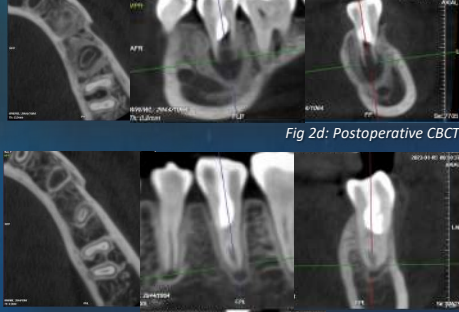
One- year recall CBCT
